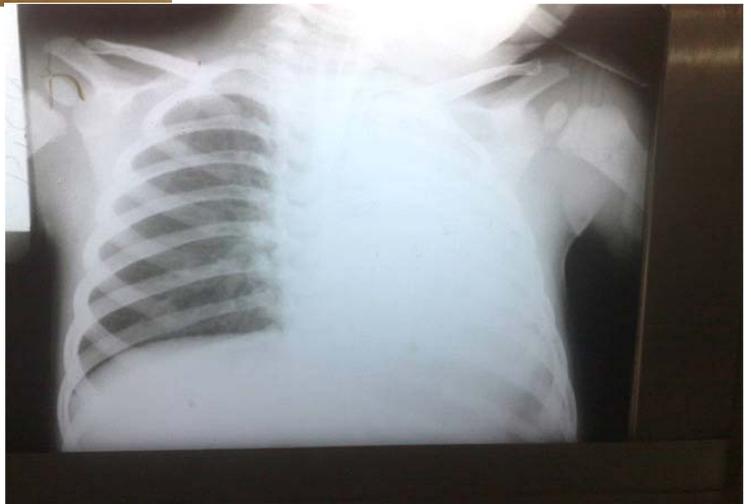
Chest X-ray showing left-sided unilateral pulmonary oedema.
